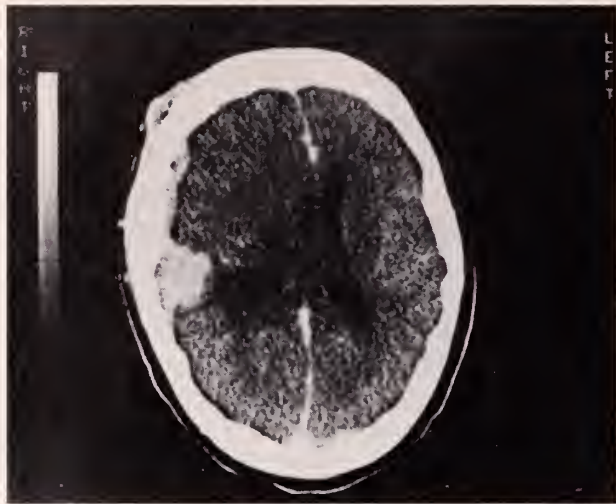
CT scan following radiation therapy.
